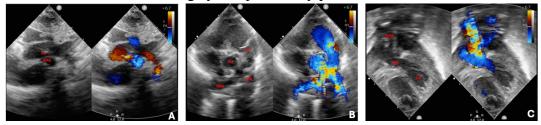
Transthoracic echocardiography Examination result (7 May 2023, at 11-day-old). A, Apical 5 chamber view shows that right pulmonary artery (RPA) arises from aorta (Ao).
